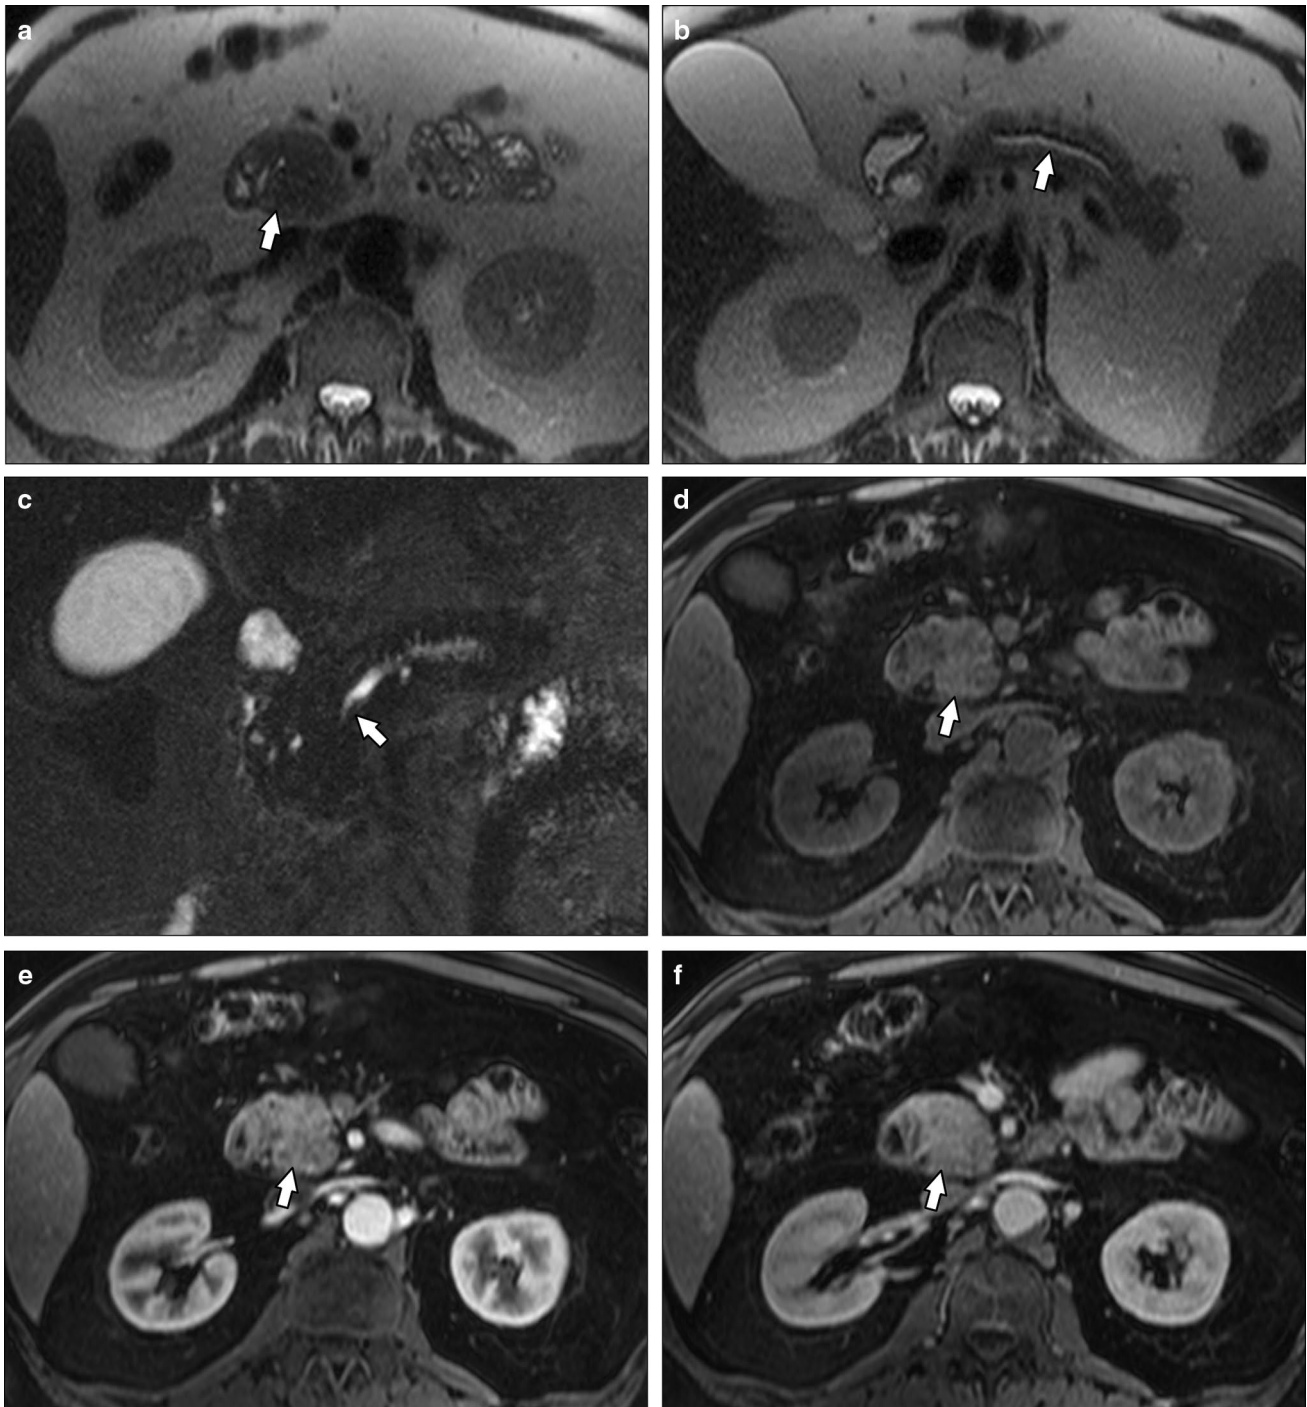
A 62-year-old man with obstructive jaundice, post placement of an indwelling biliary stent, elevated CA19-9 and IgG4. a Axial T2-weighted MR image shows heterogeneous lesion in the pancreatic head (arrow). b Axial T2-weighted MR image shows mild pancreatic duct dilatation (arrow) the degree to which is at a lesser extent than typical for a pancreatic adenocarcinoma. c MRCP images show smooth tapered narrowing of the upstream pancreatic duct mimicking
